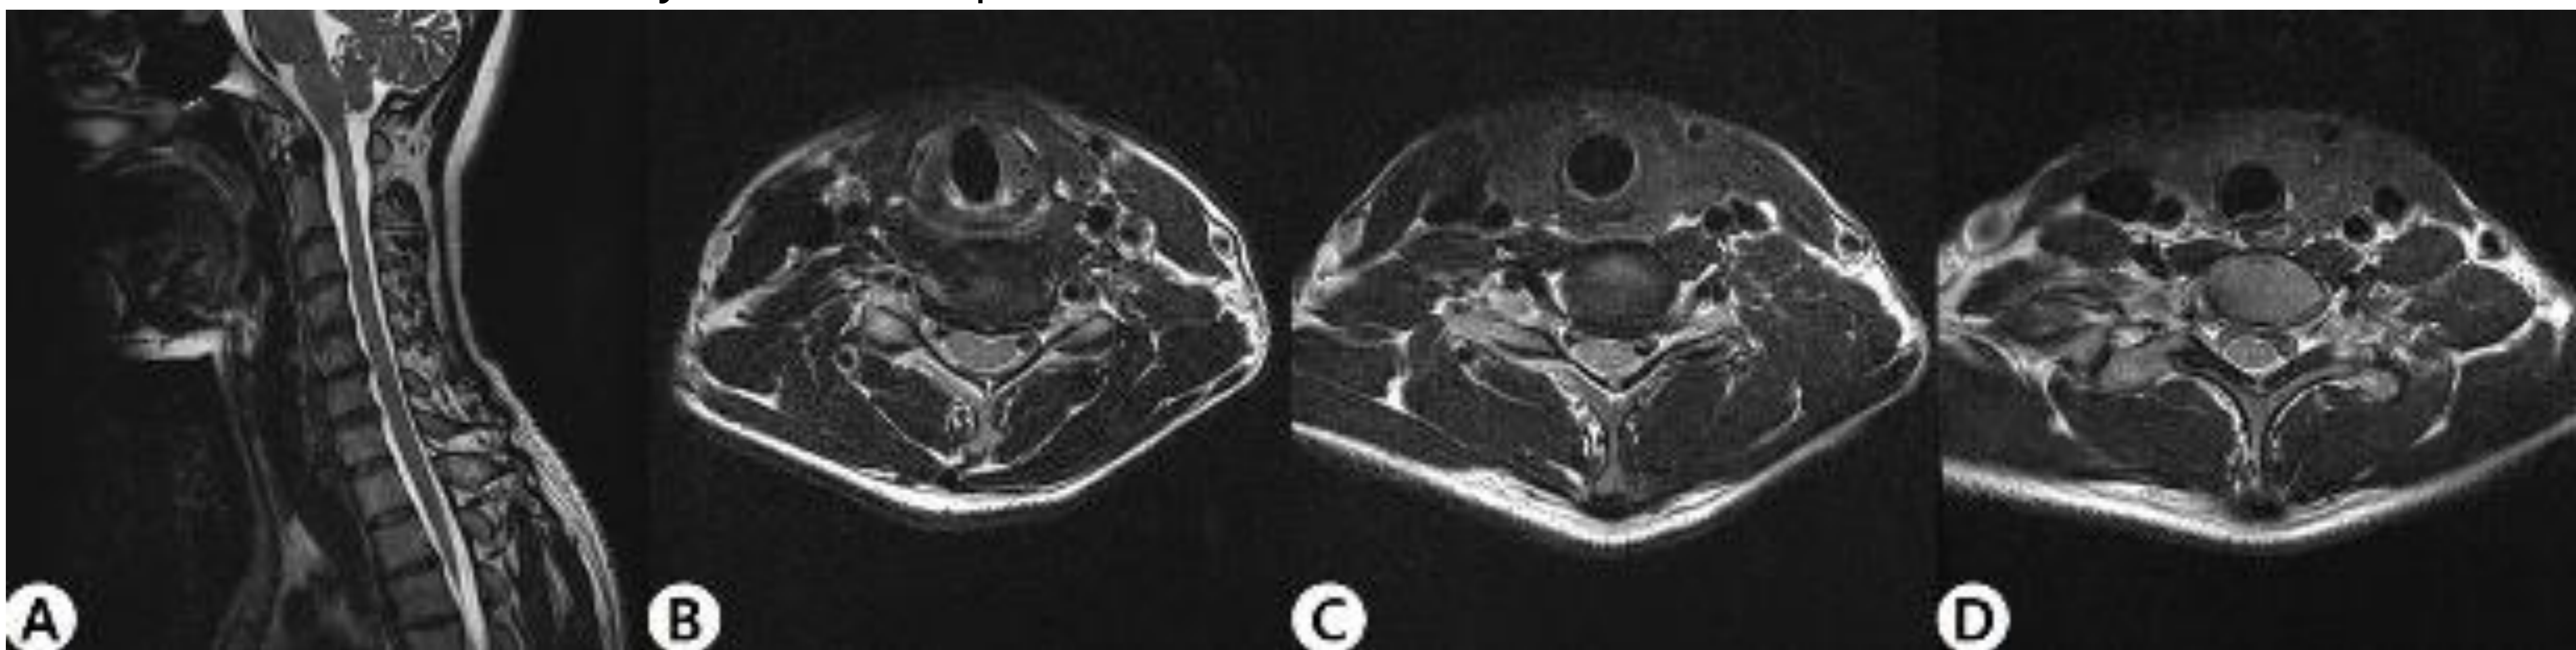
Sagittal and axial MR images of the cervical spine.
